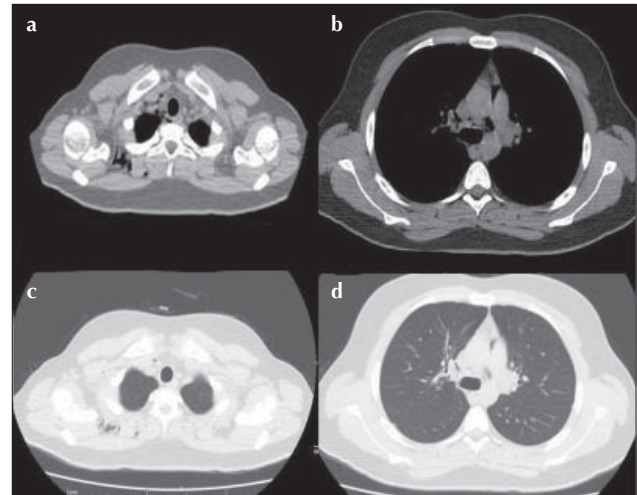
a-d. Mediastinal emphysema and subcutaneous emphysema in thoracic CT of case 2.
